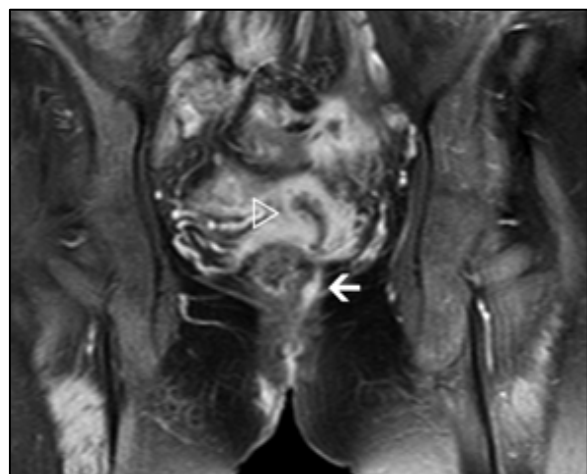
Contrast enhanced coronal MRI image It indicates the enhanced, inflamed bowel segment (hollow triangle) and the supra-levator component of the fistula (arrow). No abscess was detected
